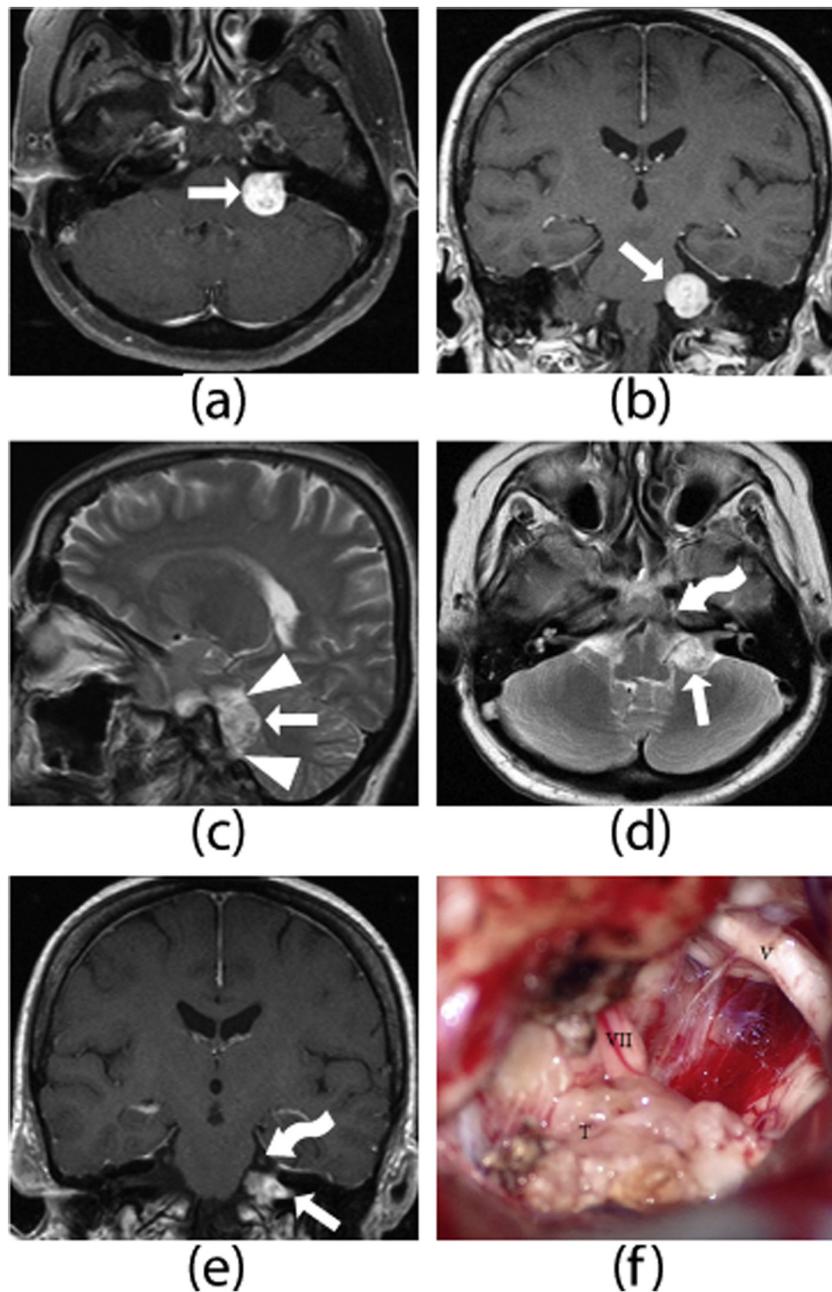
T1W MRI with intravenously administered contrast agent shows a mass with inhomogeneous enhancement (arrow) originating from the left vestibulocochlear nerve, (a) axial view, (b) coronal view. The tumor exerted a mass effect (arrowhead) on the neighboring structures, as shown by the T2W images (c), however no direct compression of the trigeminal nerve was observed (image d T2W, image e T1W contrast enhanced, curved arrows). Intraoperative photograph showing the tumor (T) and its position relative to the facial (VII) and trigeminal (V) nerves (f).
